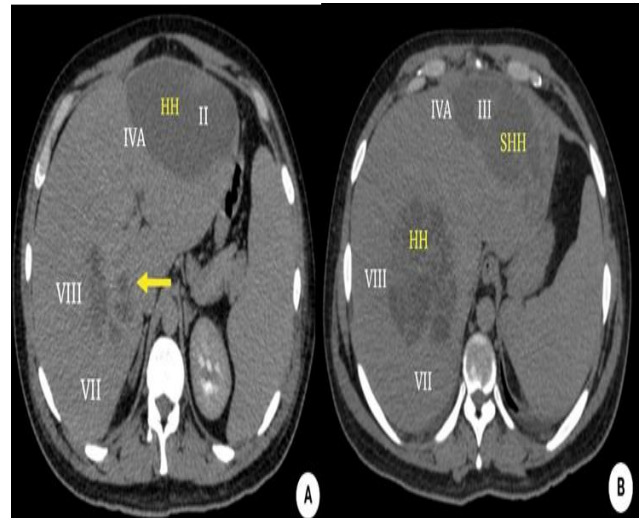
(A and B): Abdominal computed tomography (CT) showing lesions in the right and left hepatic lobe, involving segments II, III, IVA and VIII of Couinaud axial CT with presence of heterogeneous image of $124 \times 65 \times 123$ in segments II and IVA of Couinaud, compatible with hepatic hematoma (HH) and another heterogeneous lesion of $88 \times 85 \times 89$ in segment VIII of Couinaud (Arrow). Axial CT scan with hepatic mass in segment VIII of Couinaud compatible with intraparenchymal hepatic hematoma (HH); another lesion in segment III and hepatic IVA compatible with subcapsular hepatic hematoma (SHH).
